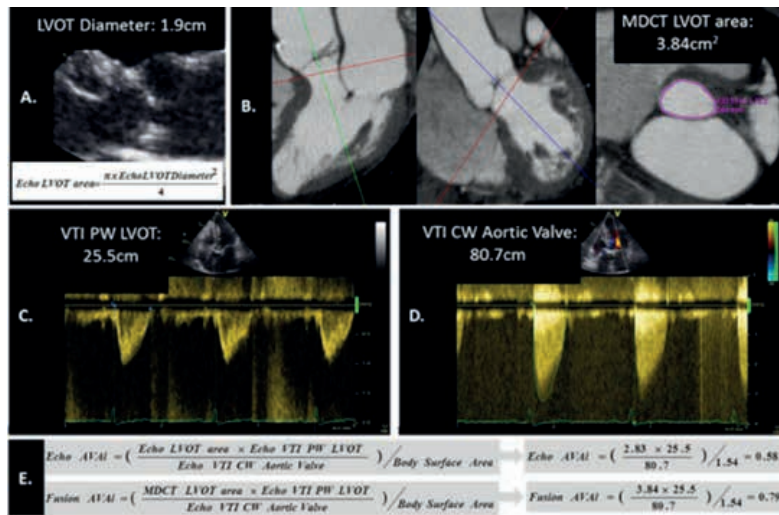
Aortic valve area index (AVAi) evaluated by echocardiography (Echo) and by fusion of multi-detector computed tomography (MDCT) and Doppler-echocardiographic data. By echocardiography, the left ventricular outflow tract (LVOT) diameter was measured 5 mm below the aortic annulus and the LVOT area was estimated (A). Using MDCT, the LVOT area was planimetered at the reconstructed double-oblique transverse view in systole, 5 mm below the annulus (B). The velocity time integral (VTI) of the flow at the LVOT was measured on pulsed wave (PW) Doppler recordings obtained from the apical 5-chamber view with the sample volume located 5 mm below the aortic annulus (C). The VTI of the flow at the aortic valve was measured on continuous wave (CW) Doppler recordings (D). By applying the continuity equation, the echo and the fusion AVAi were evaluated by using the echo-estimated LVOT area and the MDCT-derived LVOT area respectively (the Doppler hemodynamics as described in C & D were consistently used) (E).
